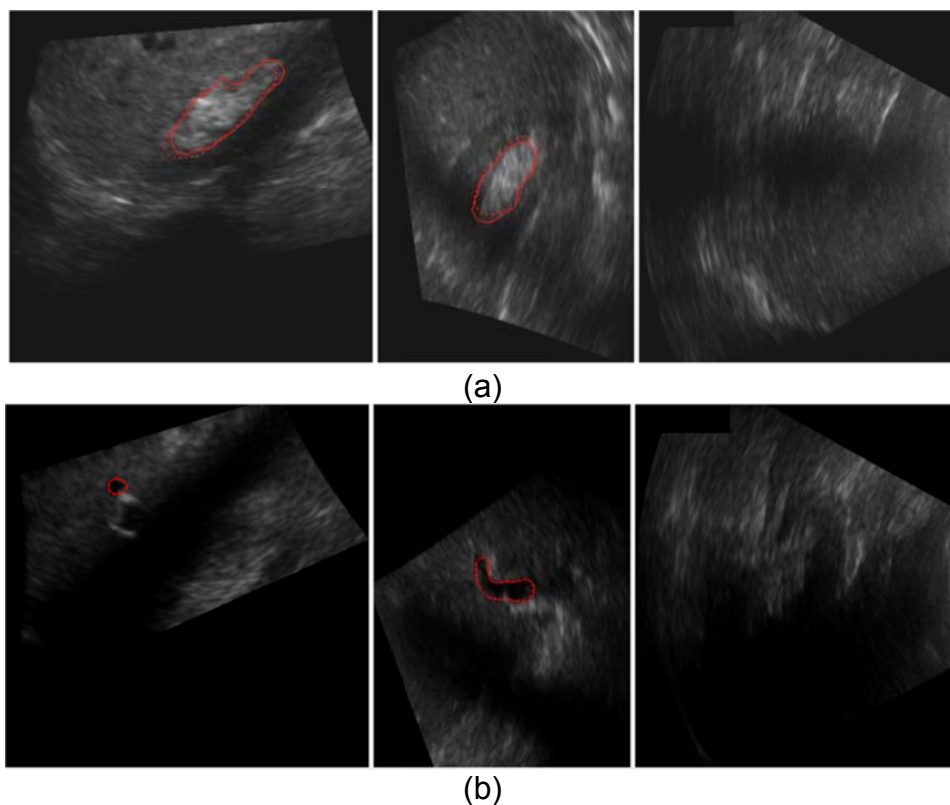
Ultrasound tracking of renal pelvis (a) and liver vein branch (b)
